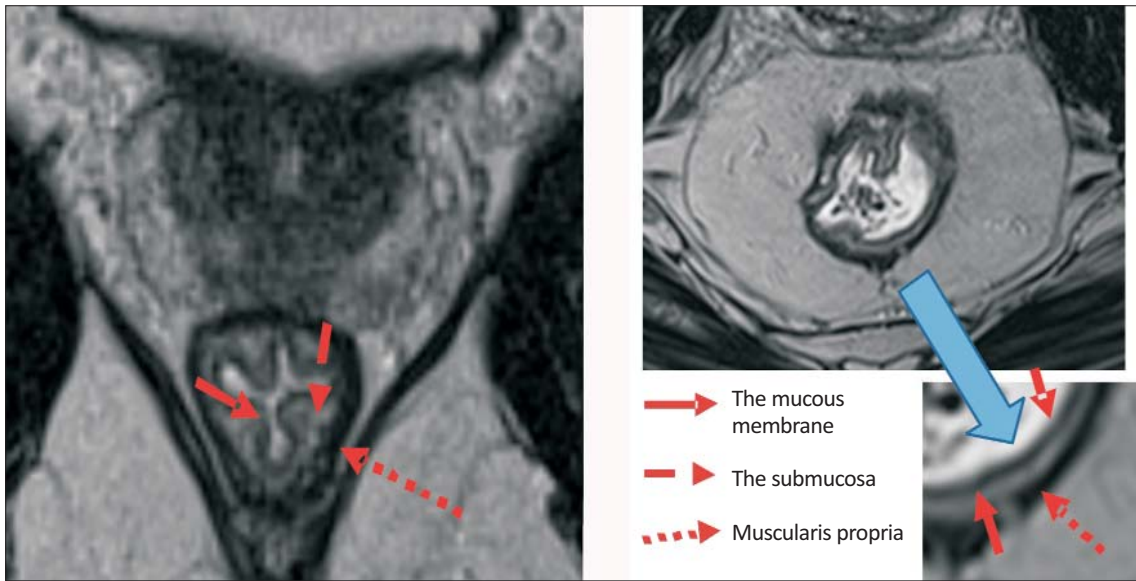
Oblique paraxial plane T2-weighted FSE image (TSE) of the pelvis showing the layers of the rectal wall. We can see the mucous membrane (closed fine line, red arrow) and the submucosa (interrupted arrow) like an outstretched strip. The muscularis propria is the hypointense "black strip" (interrupted arrow).
